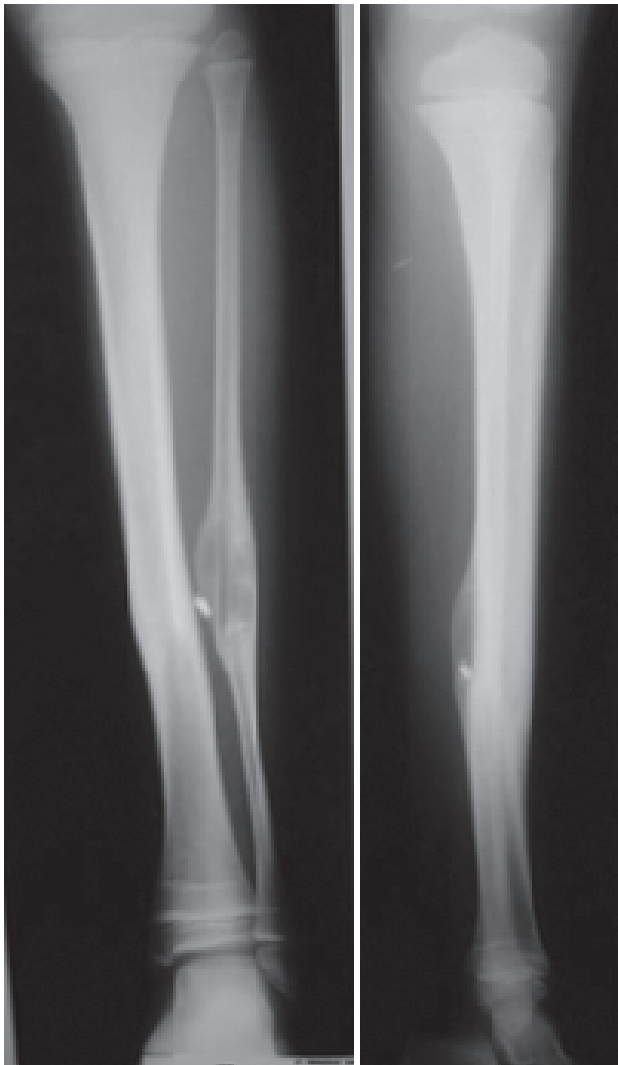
Right leg X-ray 3 months post-operative
